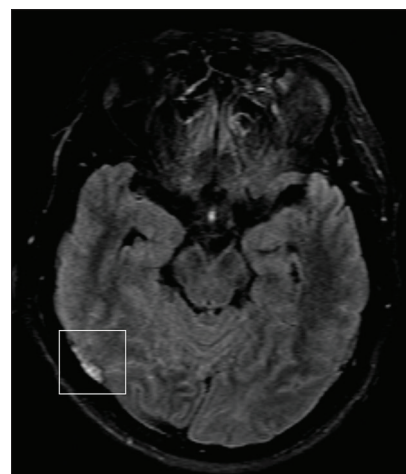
Magnetic resonance imaging showing leptomeningeal enhancement in the right temporo-occipital region
